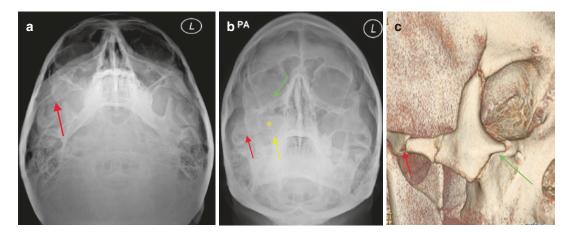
Plain radiograph OM views 10 degrees (a) and 30 degrees (b) and 3D reconstructed CT image (c) showing a right zygomatic complex fracture. There is a right zygomatic arch fracture (red arrow), right orbital floor
